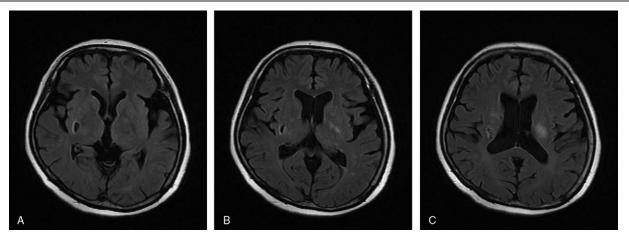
The lesions were partially resolved on a follow-up magnetic resonance imaging (MRI) examination performed 1 month after discharge. The T2-FLAIR-weighted MRI showed that the lesions in bilateral basal ganglion, thalamus, and corpus callosum were resolved (A and B). The hyperintense remained in left corona radiate (C).
